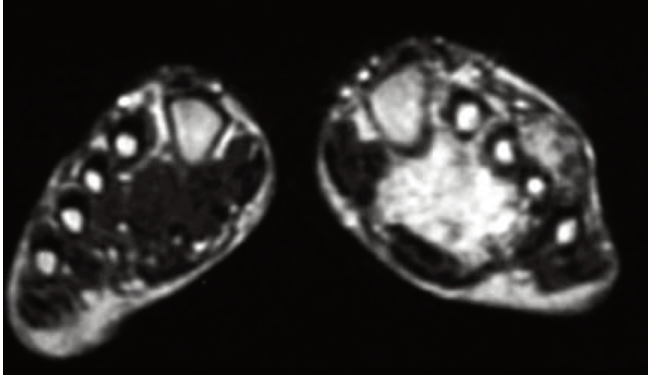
T2-weighted image of both feet demonstrating the hyperintensity of a pigmented villonodular synovitis in the plantar muscular of the arch.
